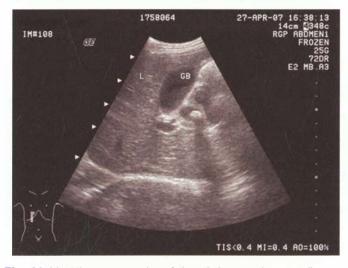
Ultrasonography of the abdomen shows gall stone with posterior acoustic shadow
